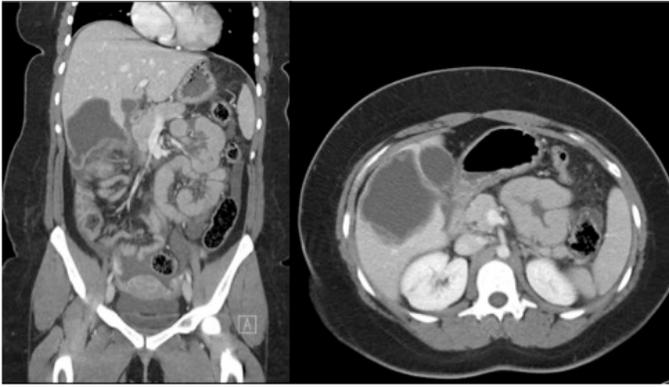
Coronal and axial sections of CT abdomen and pelvis demonstrates a solitary 8.3 x 6.4 x 8.8 cm uniloculated, hypo-attenuating, cystic mass in the right hepatic lobe with an undulating, enhancing capsule.
